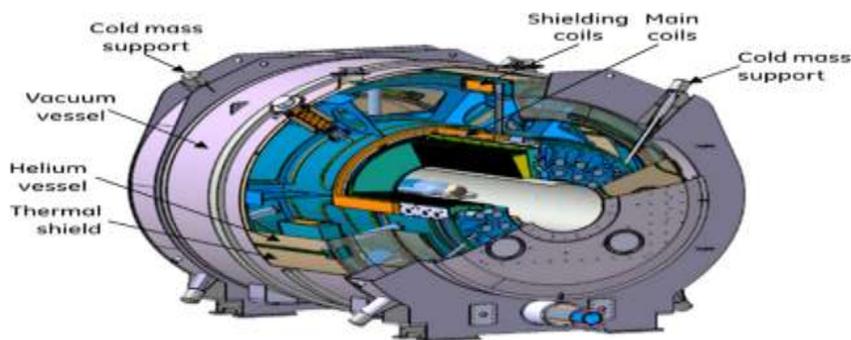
View of the 11.7 T Iseult magnet and cryostat device which maintains its low temperature. Source: Commissioning of the Iseult CEA 11.7 T whole-body MRI: current status, gradient-magnet interaction tests and first imaging experience.
